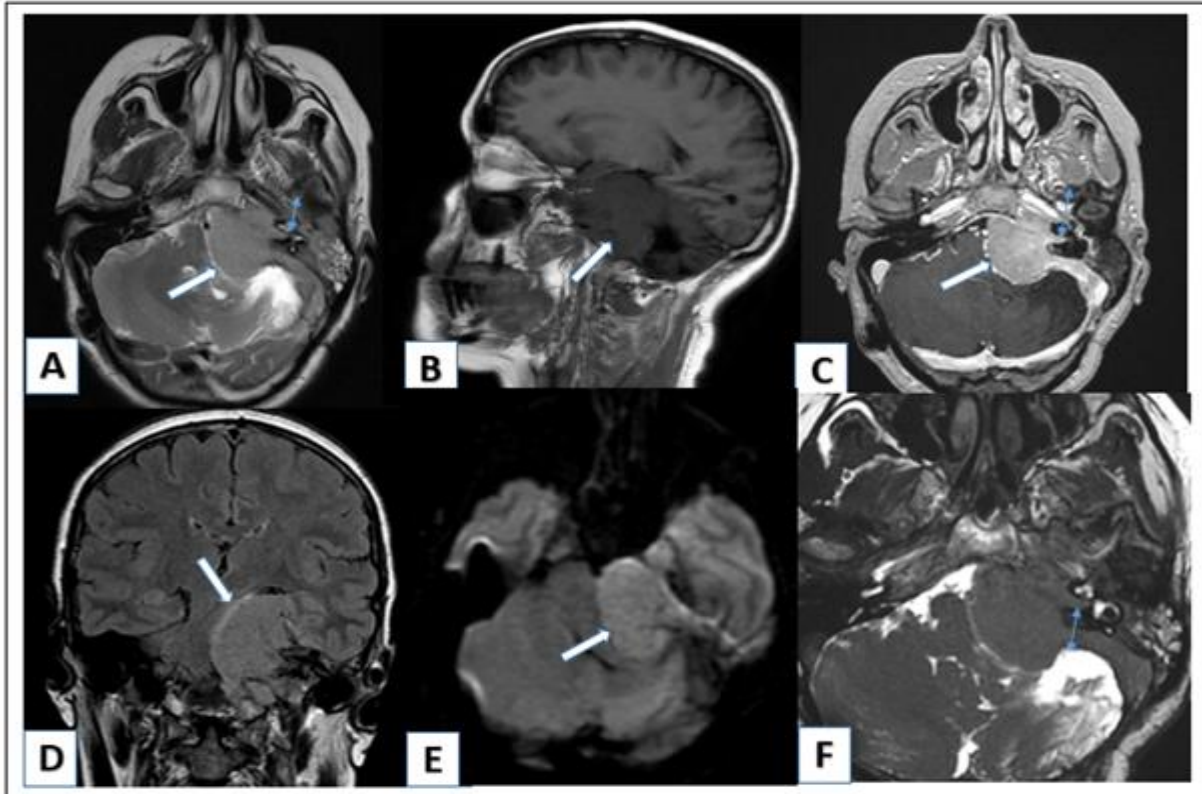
Magnetic resonance imaging appearance of an acoustic neuroma in the internal auditory canal (IAC) of the cerebellopontine angle (CPA). (A) The axial T2-weighted MR image shows the intermediate signal intensity of the mass (white arrow). (B) The sagittal T1-weighted MR image shows hyposignal and (C) contrast uptake shows a significant enhancement of the mass, (D) The coronal Flair MR image shows a mass effect on the cerebellum and trunk with low peritumor edema, considering the size of the mass (E) with light diffusion restriction. (F) Fiesta axial image shows enlargement of the porus acusticus internus by the mass, realizing the appearance of ice-cream cone (blue arrow) and extending to the cochlea and vestibule.
